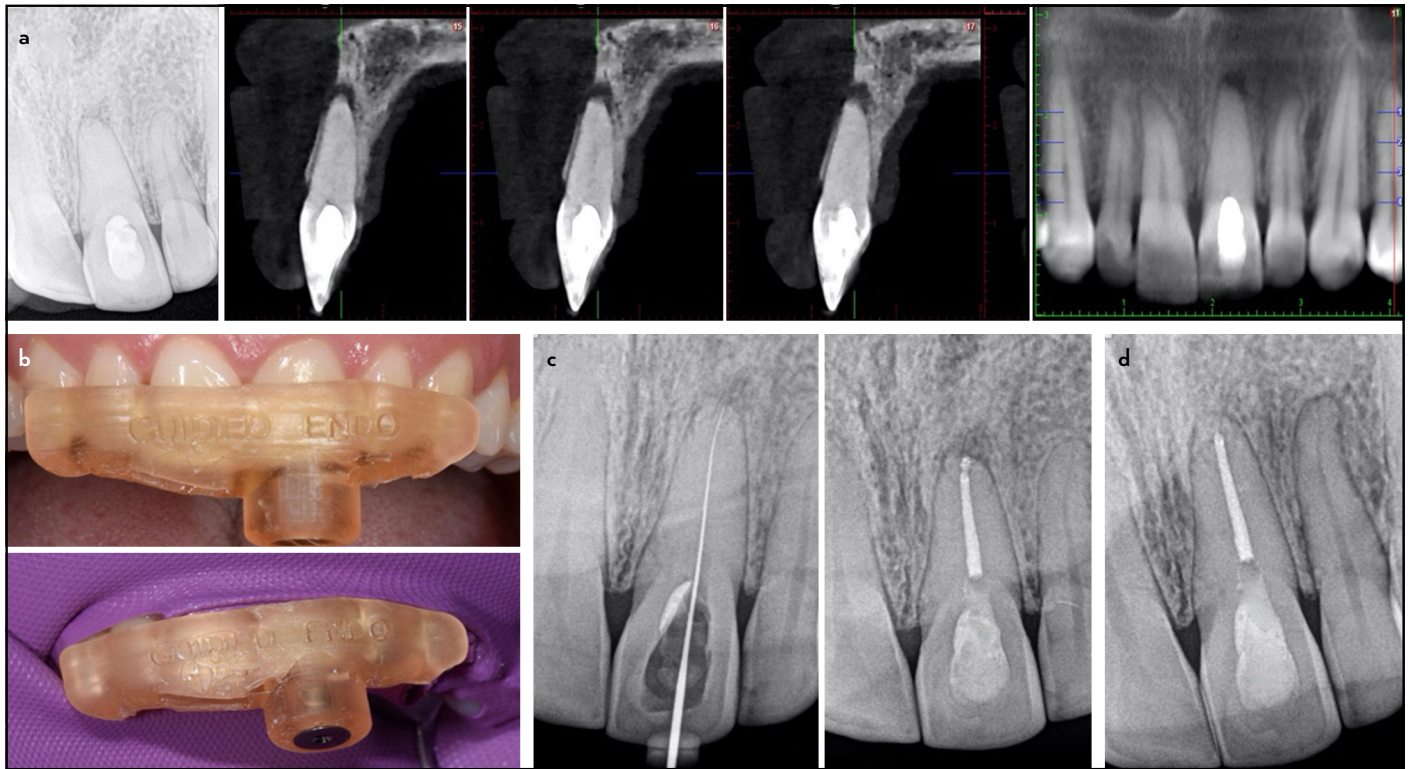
Case 6. (a) Preoperative radiograph and CBCT scan showing the degree of calcification in the root canal and the presence of a periapical lesion. (b) Fit of the template, isolation, and guided access. (c) Radiograph confirming root canal access and immediate postoperative status. (d) Follow-up radiograph at one year and six months
